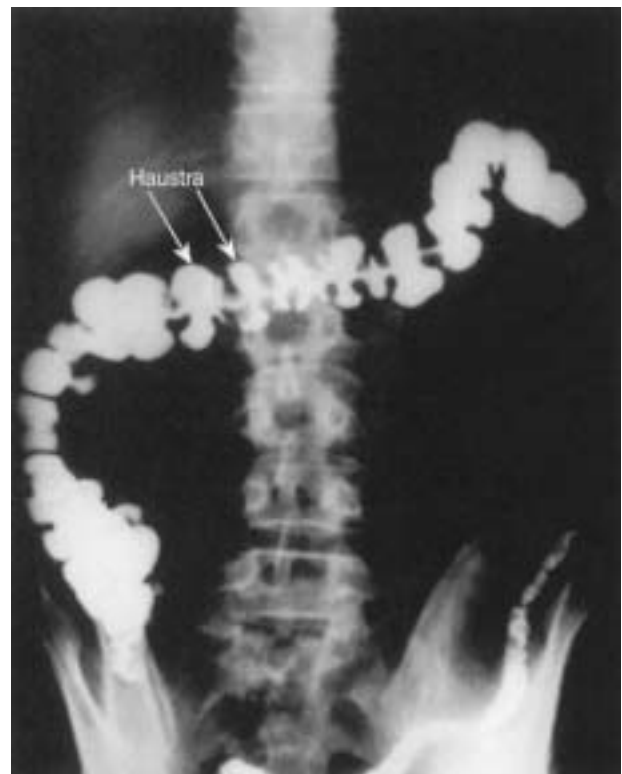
Haustra in the large intestine. This X-ray film shows haustral contractions in the ascending and the transverse colon. Between the haustral pockets are segments of contracted circular muscle. Ongoing activity of inhibitory motor neurons maintains the relaxed state of the circular muscle in the pockets. Inactivity of inhibitory motor neurons permits the contractions between the pockets.
